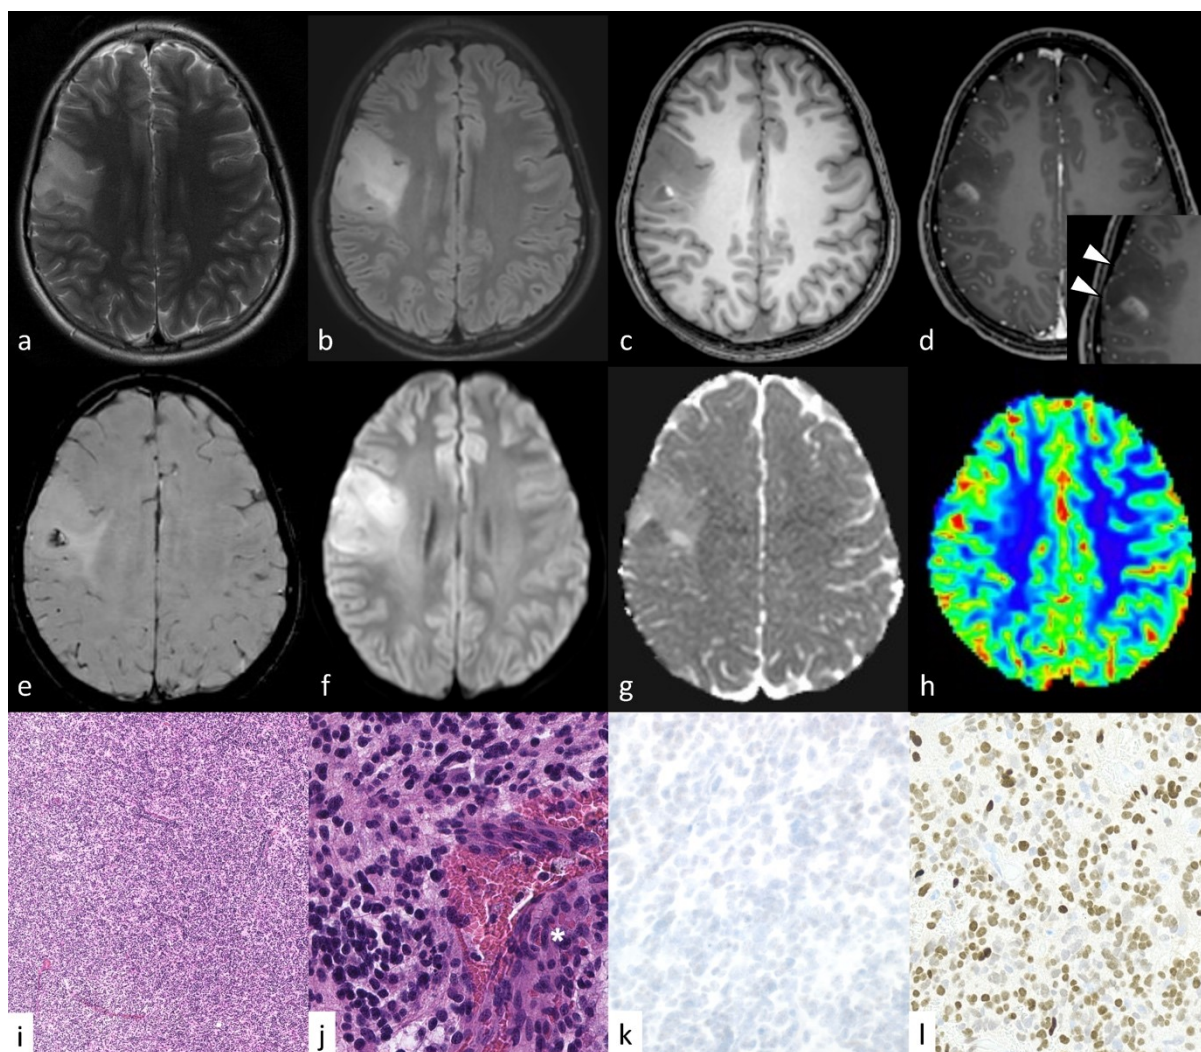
Diffuse hemispheric glioma, H3 G34R-mutant in a 16-year-old female presenting with left face twitching (case 1). MRI shows a $4.0 \times 3.7 \times 3.6$ cm tumor with leptomenigeal contact laterally (d, arrowheads in the magnified view) and an ill-defined margin medially in the right frontal lobe. The tumor shows hyperintensity on T2-weighted image (a) and a fluid-attenuated inversion recovery image (b) and hypointensity on T1-weighted image (c).
